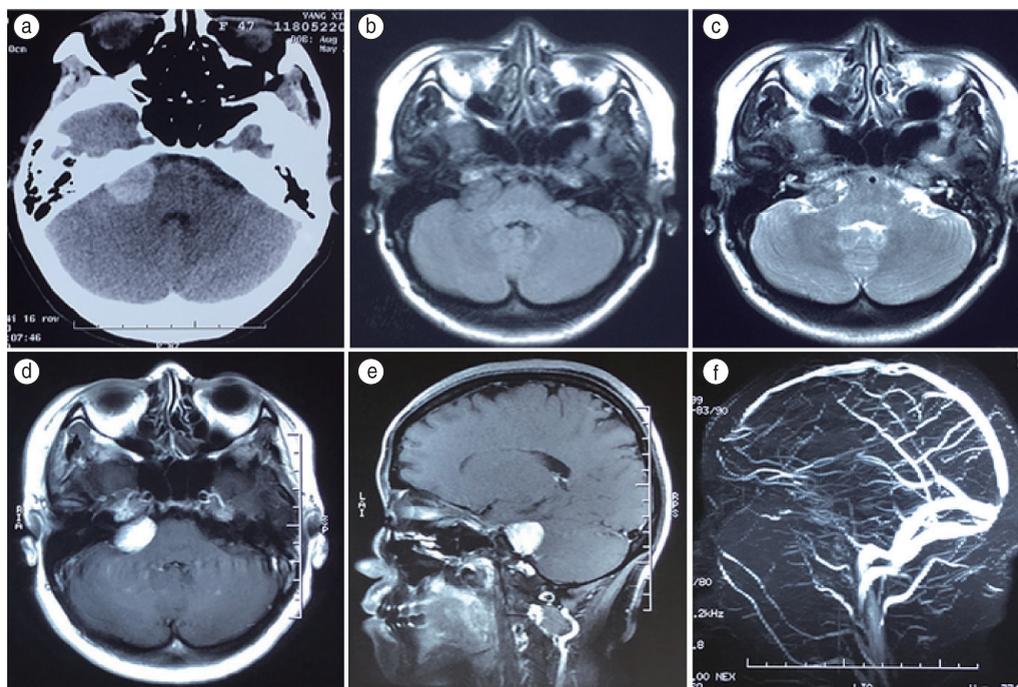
Imaging findings (a) CT showed a hyperdense and well-circumscribed lesion in the right cerebellopontine angle (CPA) region; (b and c) The lesion was isointense on T1-weighted sequences (b) and of mixed signal intensity on T2-weighted sequences (c); (d and e) T1-weighted images presented intense and homogenous enhancement in the right CPA; (f) Magnetic resonance angiography (MRA) scan showed no obvious abnormality
